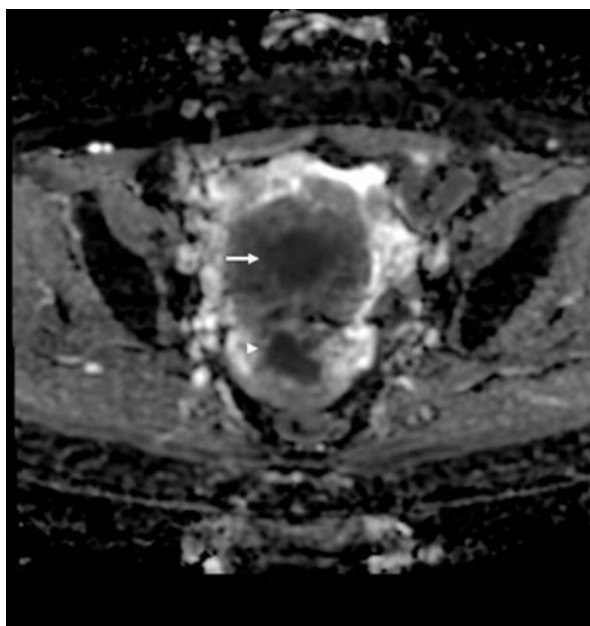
Magnetic resonance imaging (MRI) apparent diffusion coefficient (ADC) map sequence; axial section showing low ADC values in the cervical mass (white arrowhead) and uterine corpus mass (white arrow). The masses had similar low ADC values, but the cervical mass had a slightly lower ADC value compared with the uterine corpus mass.
